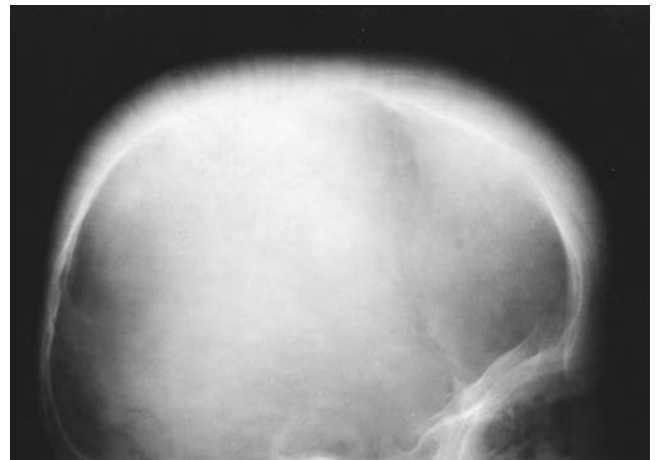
Radiograph of the skull. In the frontal area, the bone has a lamellated structure, parallel to the inner table of the diploe. In the parietal area, erythroid hyperplasia has perforated the outer table, producing a characteristic “hair on end” appearance. (Courtesy of Dr. C. Orzincolo.)
